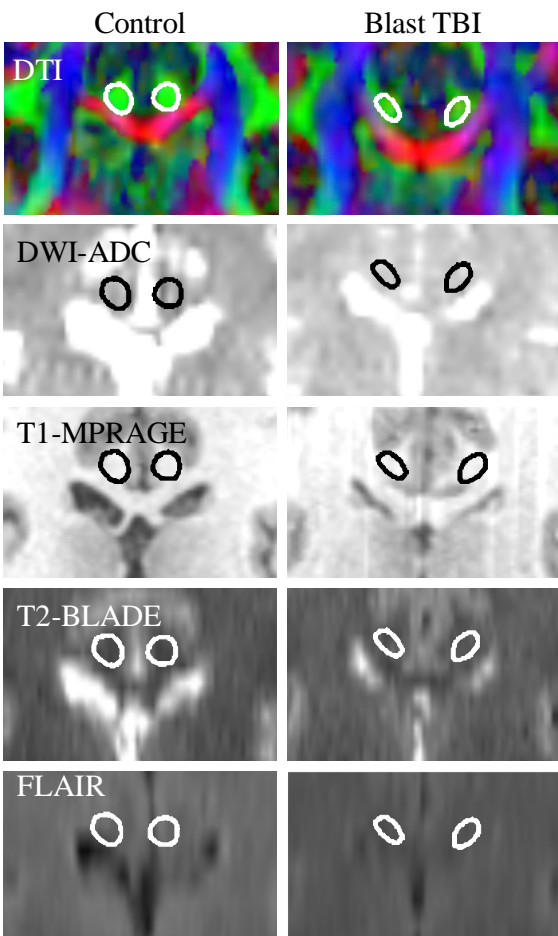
Acute blast-related TBI patient with apparent traumatic axonal injury in the cingulum bundles bilaterally (outlined). DTI signal abnormality is indicated by less intense green signal in comparison to a control subject. No abnormalities were seen on conventional MRI (DWI-ADC, T1-MPRAGE, T2-BLADE, FLAIR) in this region.
